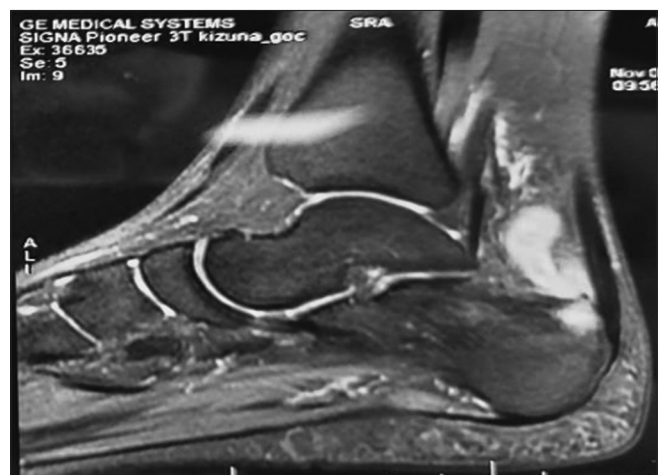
Sagittal section of magnetic resonance imaging ankle suggestive of bony and soft tissue involvement.
